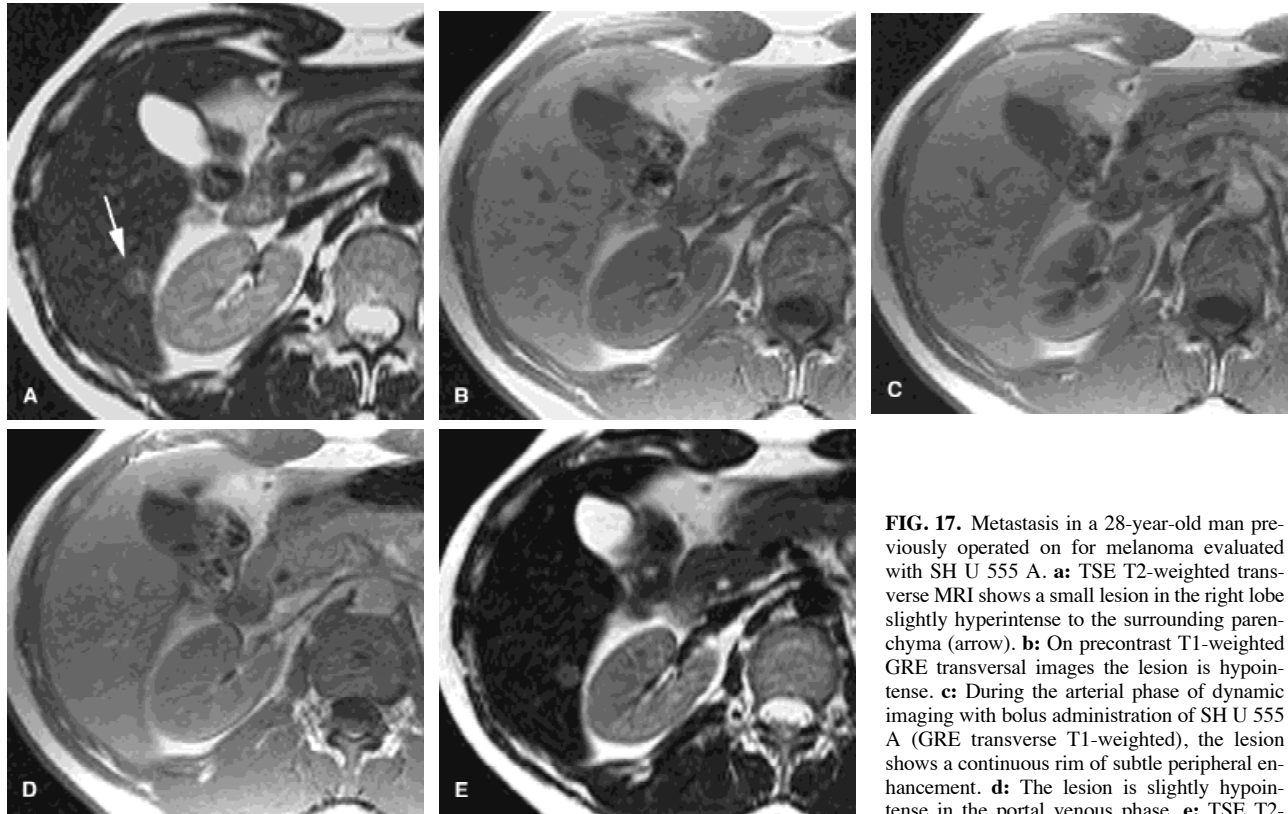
Metastasis in a 28-year-old man previously operated on for melanoma evaluated with SH U 555 A. a: TSE T2-weighted transverse MRI shows a small lesion in the right lobe slightly hyperintense to the surrounding parenchyma (arrow). b: On precontrast T1-weighted GRE transverse images the lesion is hypointense. c: During the arterial phase of dynamic imaging with bolus administration of SH U 555 A (GRE transverse T1-weighted), the lesion shows a continuous rim of subtle peripheral enhancement. d: The lesion is slightly hypointense in the portal venous phase. e: TSE T2-weighted transverse MRI 10 minutes after SH U
